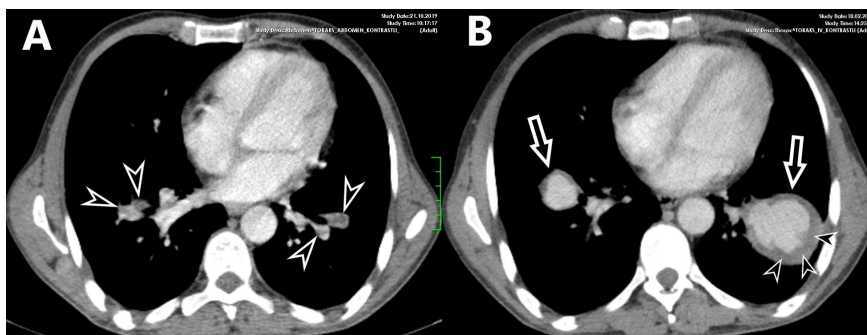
In a 58-year-old male patient diagnosed with Hughes Stovin Syndrome, filling defects (arrowheads) consistent with embolism are observed in the pulmonary artery lumen in both lower lobes of the lung on contrast-enhanced thorax CT (A). On the thorax CT taken approximately 3 months later, aneurysms developing after thrombus including partial thrombus areas (arrowheads) are observed in the same localizations (B).
